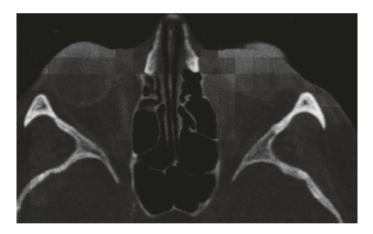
Bone window of axial CT-scan
